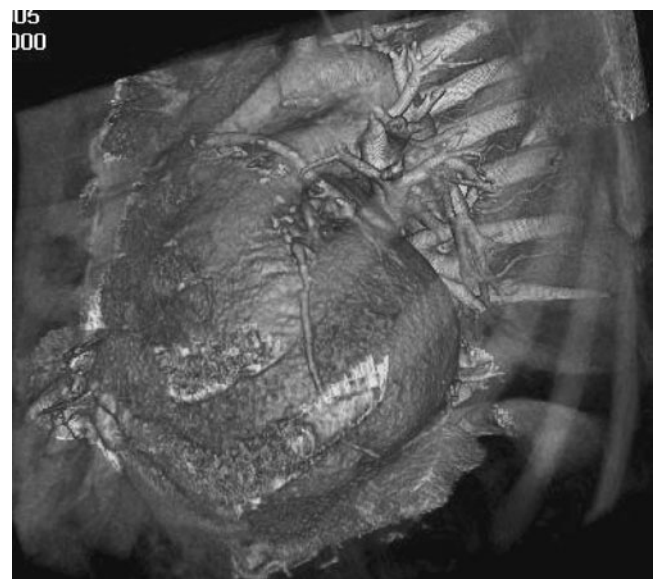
Preoperative planning for minimally invasive cardiac surgery (MIDCAB). Specialized display protocols for 3-D volume-rendered images can be used to provide combined visualization of a semitransparent thoracic cage and underlying cardiac and mediastinal structures. These models can be rotated and viewed from any angle or degree of magnification. With cardiac CT, 3-D localization of target vessels, accessibility from proposed incision site, and position of left ventricular apex with respect to chest wall all can be understood preoperatively.
